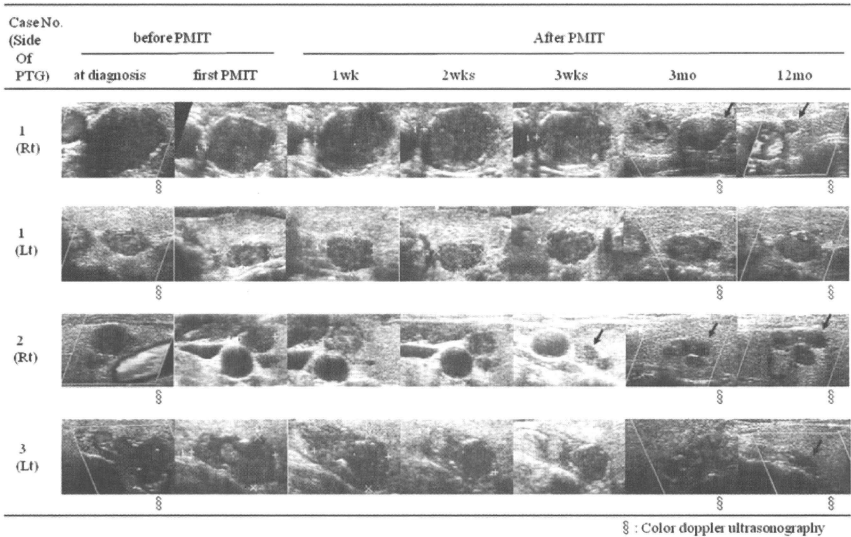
Ultrasonographic changes of the parathyroid glands with percutaneous maxacalcitol injection therapy (PMIT). The parathyroid gland (PTG) volume initially increased during the first week. Thereafter, the parathyroid gland volume gradually decreased with wPMIT. Twelve months later, it had decreased conspicuously in case 1 (right), case 2 (right), and case 3 (left), but case 1 (left) displayed almost no change.
